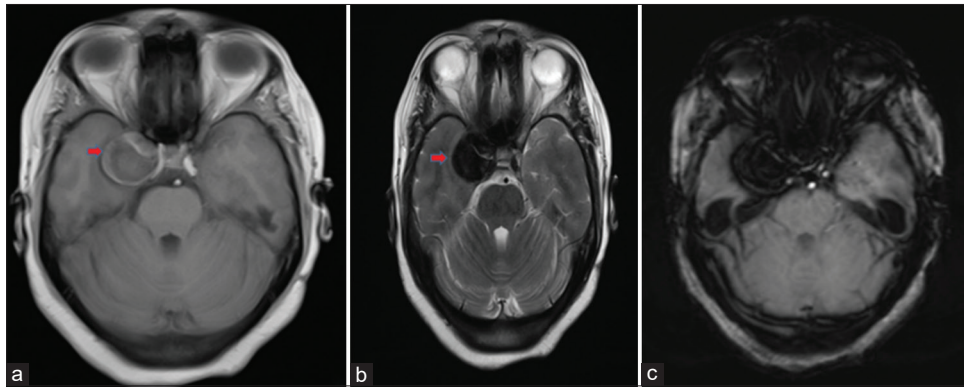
(a) T1-weighted axial magnetic resonance imaging (MRI) image showing a saccular aneurysmal dilatation of the right ICA having a peripheral hyperintense rim (blood) with hypointense center; (b) T2-weighted axial MRI image showing hypointensity in the aneurysmal dilatation; (c) Susceptibility-weighted imaging (SWI) MRI - The image demonstrates a large thrombus within the intra-cavernous segment of the right ICA, appearing as a markedly hypointense (black) area with blooming artifact on SWI, consistent with hemosiderin deposition and chronic thrombus formation
